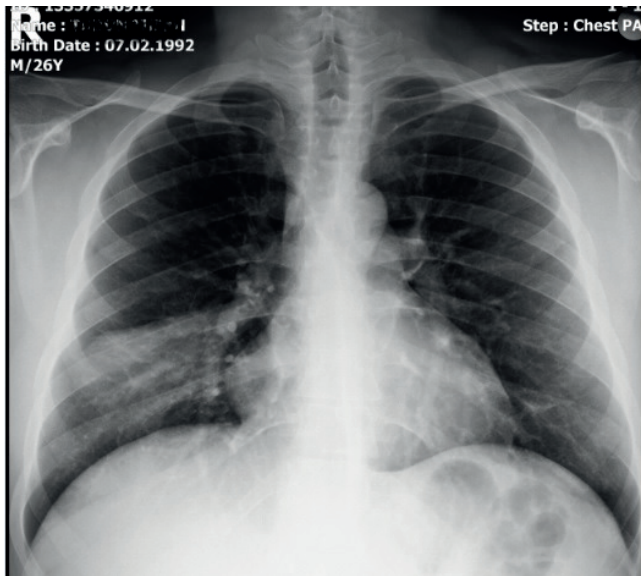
PA chest radiography findings at admission
